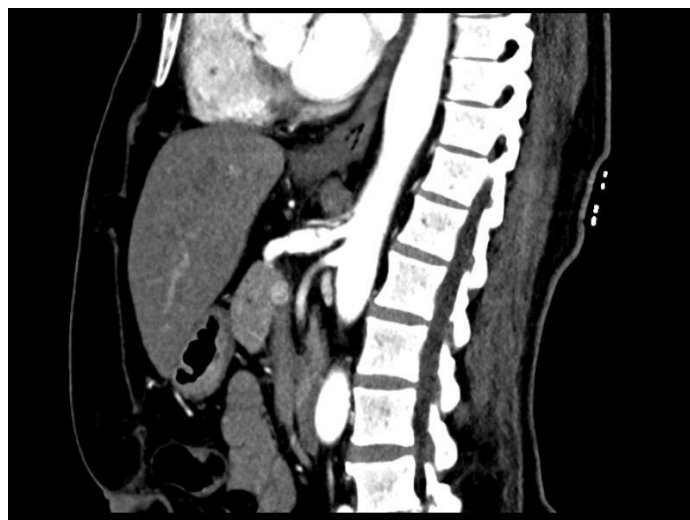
Abdominal CT scan showing celiac artery dissection
